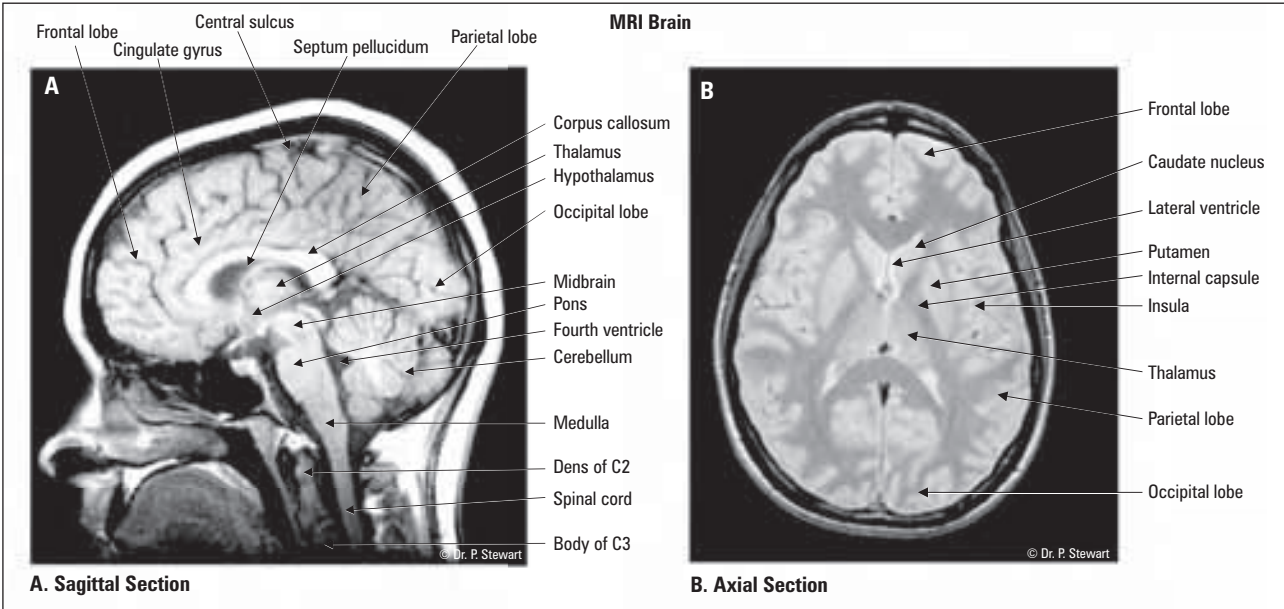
MRI Neuroanatomy
